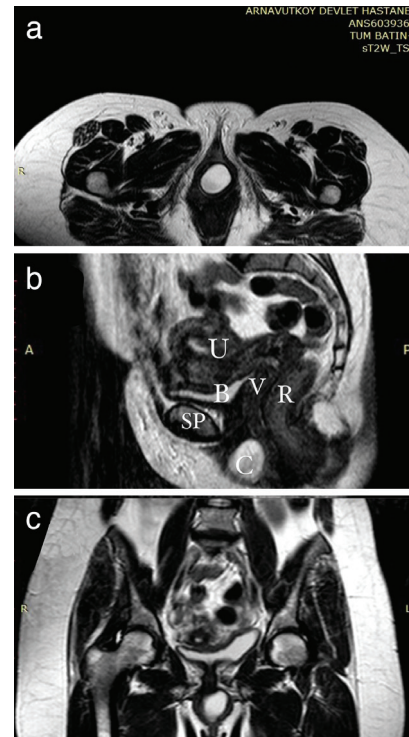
(a) Axial sT2W-Turbo spin echo contrast enhanced magnetic resonance imaging (MRI) showing a 30x27x30 mm cystic mass in the anterior introitus containing T2 hyper-intensity without any connection with the urethra. (b) Sagittal sT2W-Turbo spin echo contrast enhanced MRI showed high-intensity on St2w1 (low-intensity on sT1W1) without any diffusion restriction. A 30 mm oval mass is located inferior to the symphysis pubis and lateral to the external urethral meatus (B: Bladder, C: Cystic mass, R: Rectum, U: Uterus, V: Vagina). (c) Frontal sT2W-Turbo spin echo contrast enhanced MRI demonstrating a well-contoured, cystic mass, located slightly to the left side in the periurethral region
